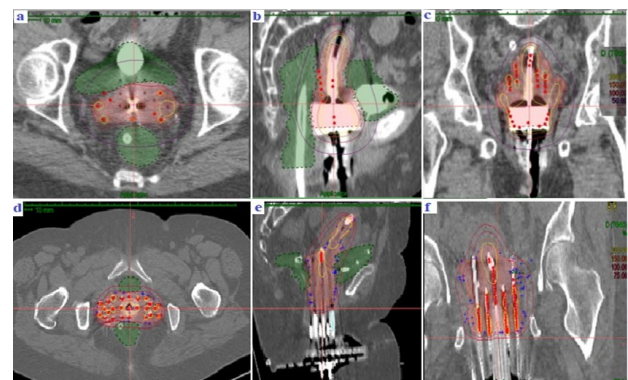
Dose distribution for Medanta AOLO application with (a) axial, (b) coronal and (c) sagittal section of CT images shows the target point optimization with manual local graphical optimization. Dose distribution for MUPIT application with (d) axial, (e) coronal and (f) sagittal section shows the basal dose point optimization with manual local graphical optimization.
